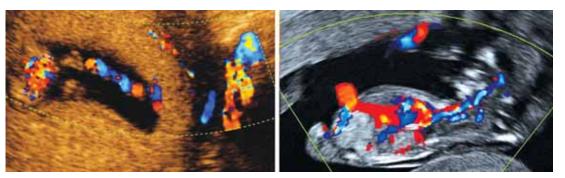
2D color flow sonogram shows intervillous circulation in the maternal site of placenta at 9 weeks of gestation with intense vascular activity. Visualization of the umbilical cord and its vascularization are also seen. On the right, 2D color flow TV sonogram of a fetus at 11 weeks of gestation. Umbilical vein can be followed from the abdominal umbilical insertion through the fetal liver and ending below the heart. Cerebral circulation can also be visualized in the first trimester³
